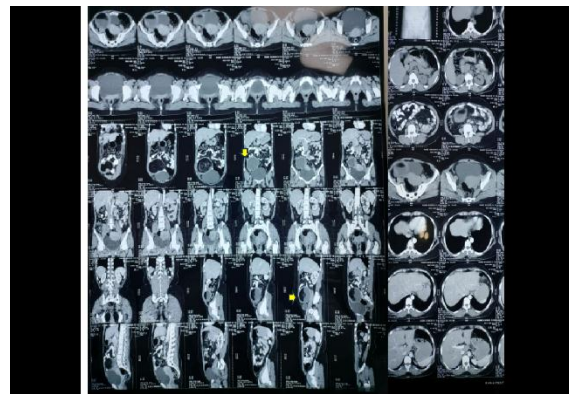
CT scan coronal and sagittal sections showing adnexal mass with normal uterus (mass is indicated with yellow arrow)
